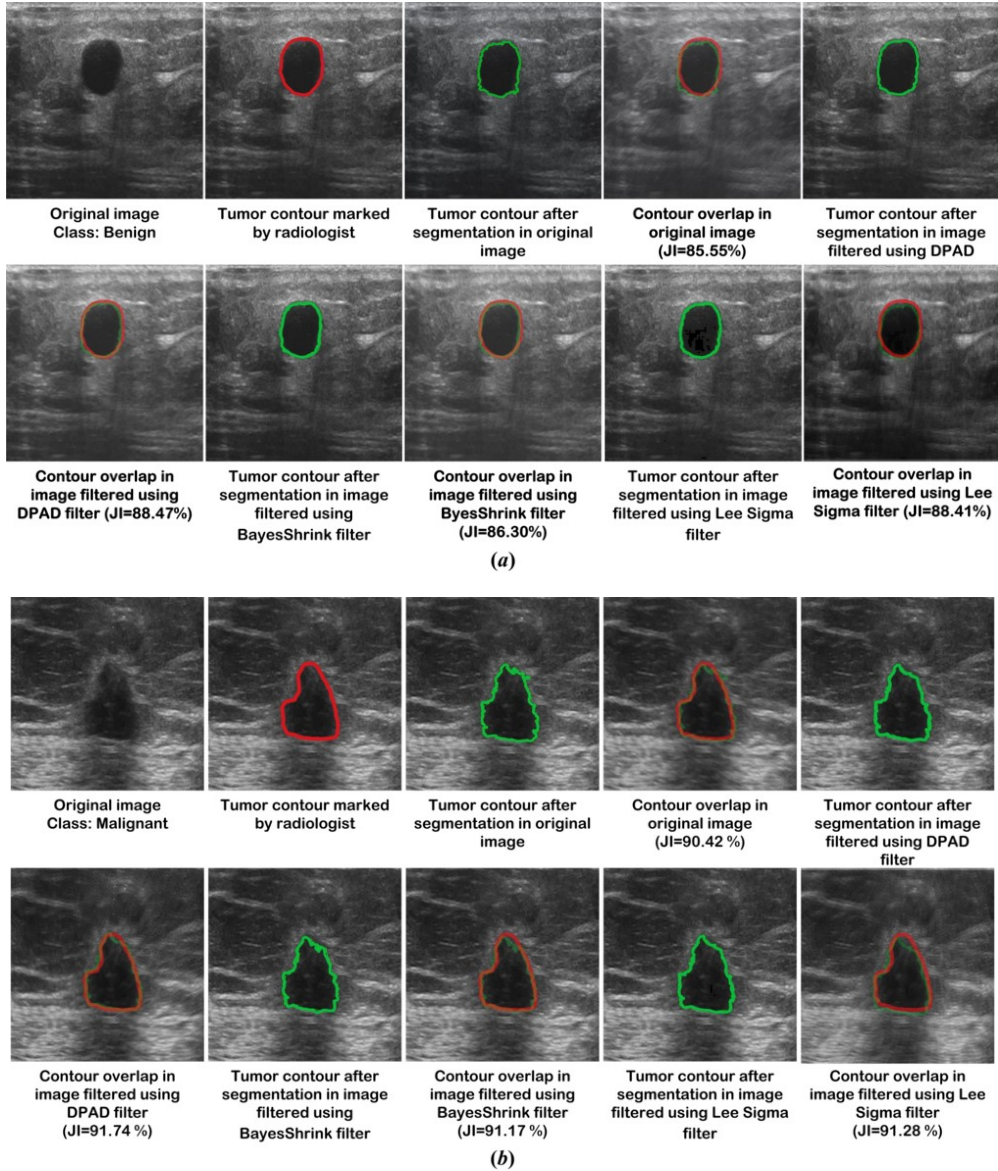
Sample breast ultrasound images indicating tumor boundary marked by radiologist (*red*) and tumor boundary obtained using segmentation algorithm (*green*). (a) Benign ultrasound image, (b) Malignant ultrasound image.
